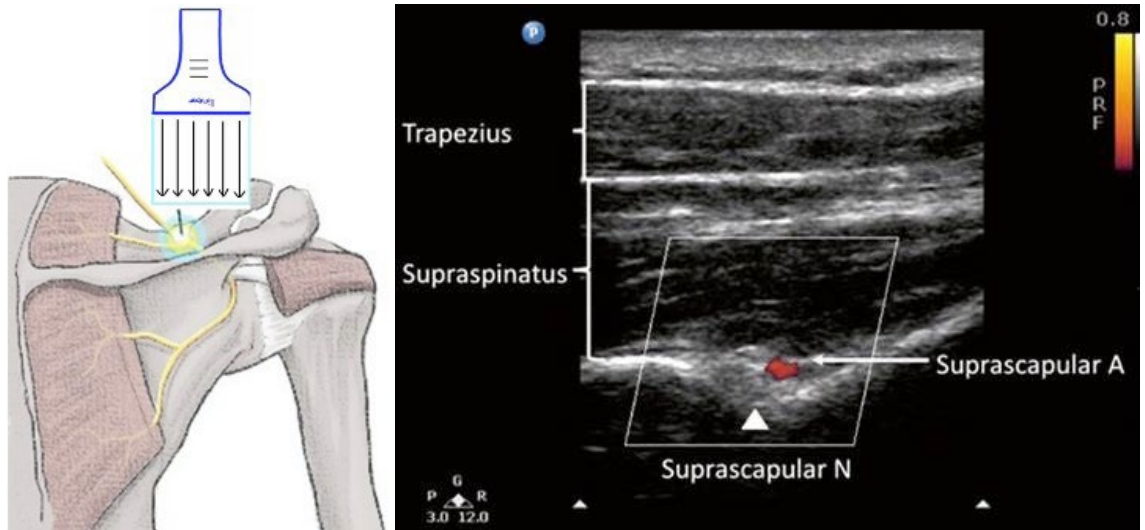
Suprascapular nerve exiting through the scapular notch. The scapular notch is an area of loss of bony sonography and the presence of a pulsatile artery indicating a neurovascular bundle
